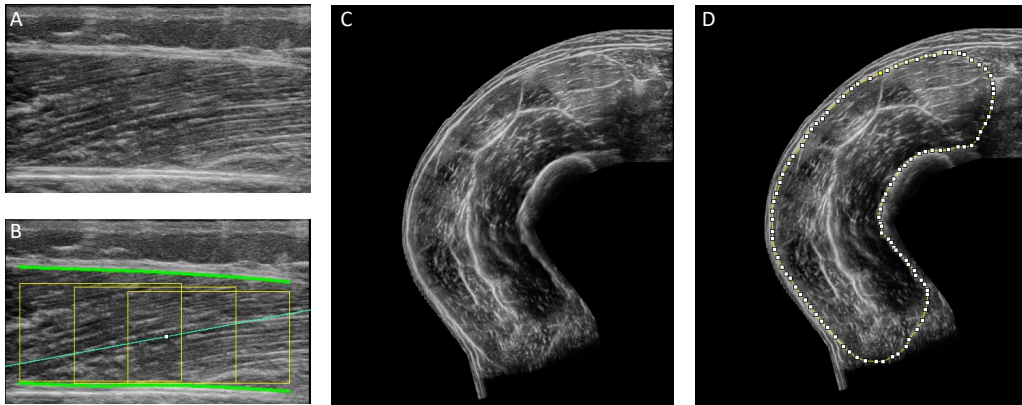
Quadriceps ultrasound
